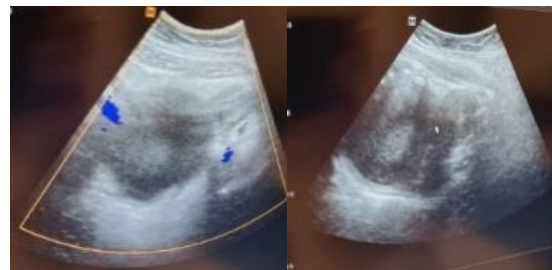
Pelvic ultrasound examination revealed an enlarged pelvic mass 6cm and Doppler imaging showed flow in the wall with negative intra-cyst. Solid mass (3 cm) was found in the right ovary and another mass (3 cm) was found in the left ovary.
